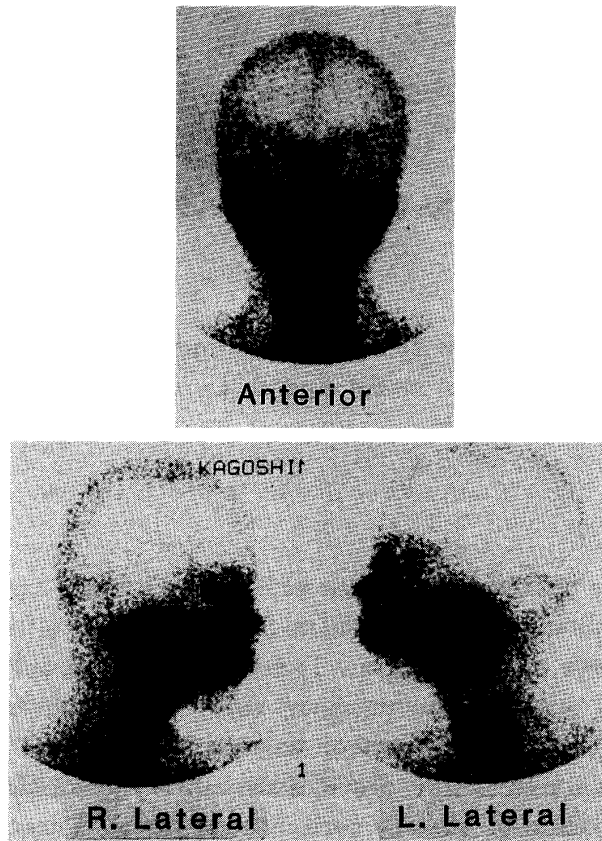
Static Images of Sialoscintigraphy
